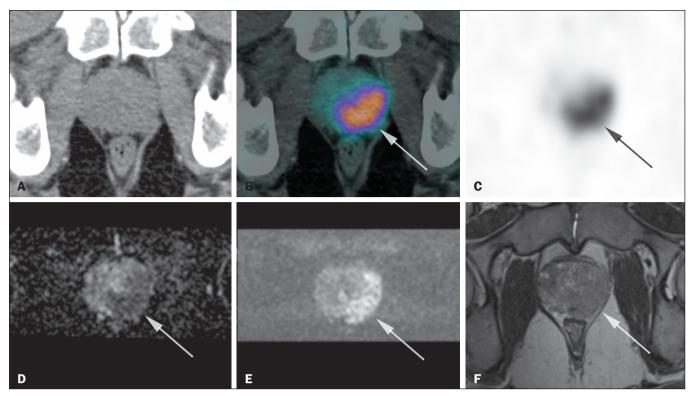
A 64-year-old patient with a serum PSA of 12 ng/mL, who presented with an altered digital rectal examination on the left. The image shows increased radiopharmaceutical uptake in a lesion predominantly in the left half of the prostate, from the apex to the base, with an SUVmax of 21.9 (A: CT; B: ⁶⁸Ga-PSMA PET/CT + CT fusion; C: ⁶⁸Ga-PSMA PET/CT), which corresponds to an infiltrative lesion affecting the peripheral and transition zones, from the apex to the base, measuring 4.3 cm on its longest axis, showing low signal intensity on T2-weighted imaging and restricted diffusion on diffusion-weighted imaging, with extra-prostatic extension, categorized as PI-RADS 5 on mpMRI (D: apparent diffusion coefficient map; E: diffusion-weighted image; F: T2-weighted image).
